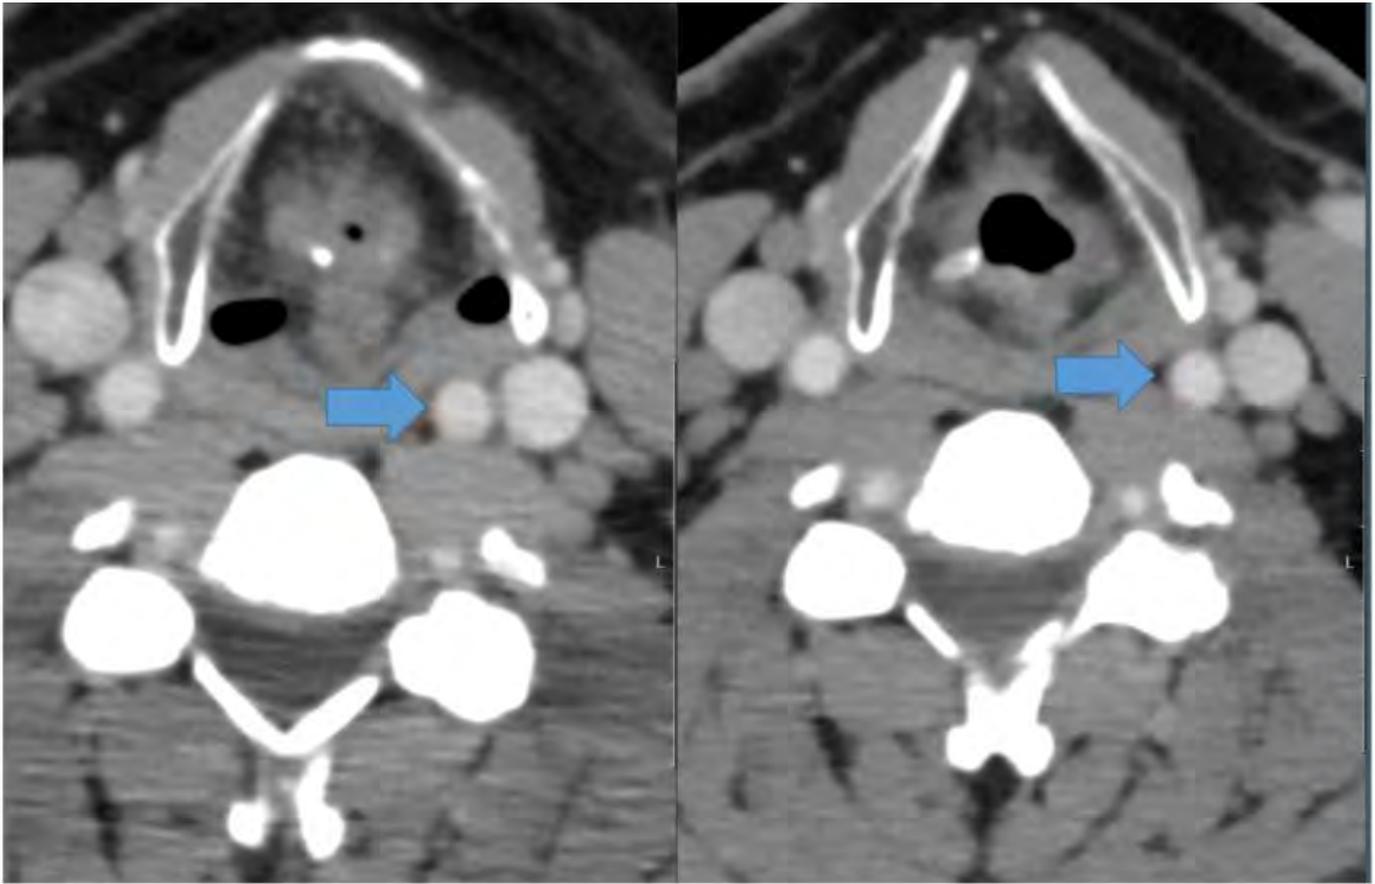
Example of the wandering carotid artery. Movement of the left common carotid artery (blue arrow) on 2 CT neck studies performed approximately 5 months apart.
